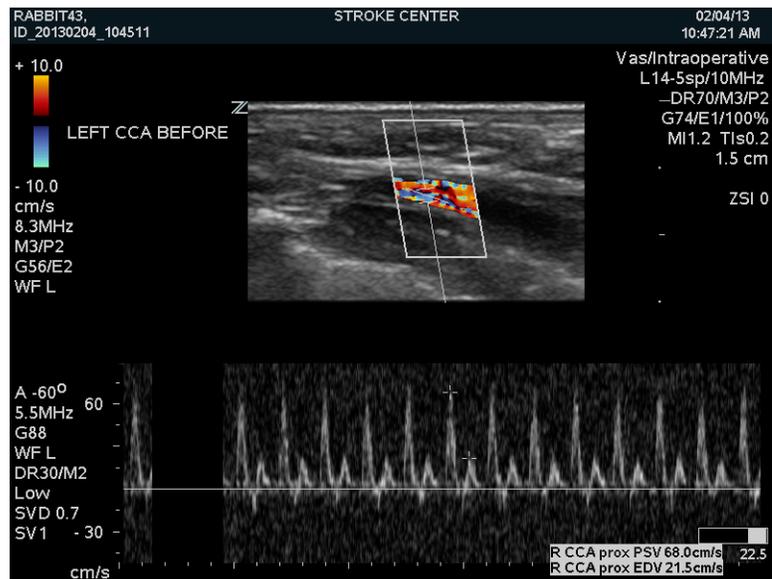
The ultrasound Pulse Wave Doppler mode is used to measure blood flow in arteries of interest.
